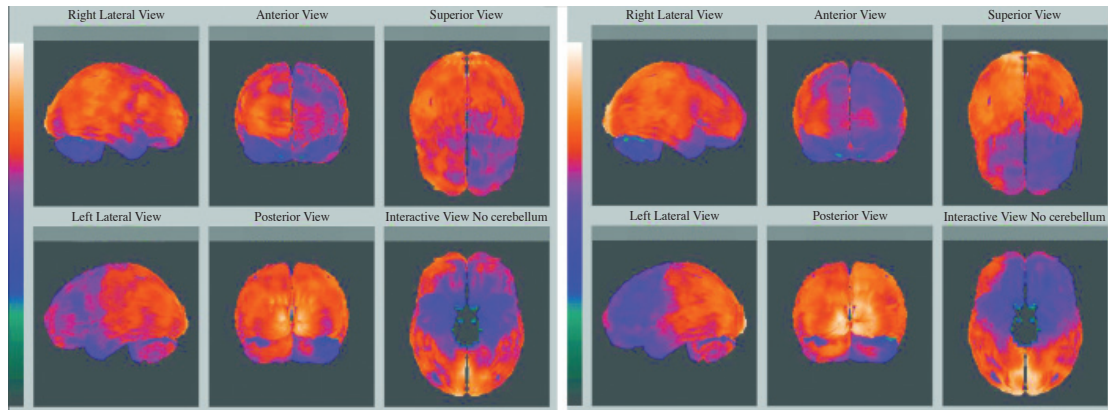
The brain single-photon emission computed tomography images show areas with hypoperfusion in the frontal lobes bilaterally (left). Images after Diamox infusion reveal no significant perfusion changes (right).
